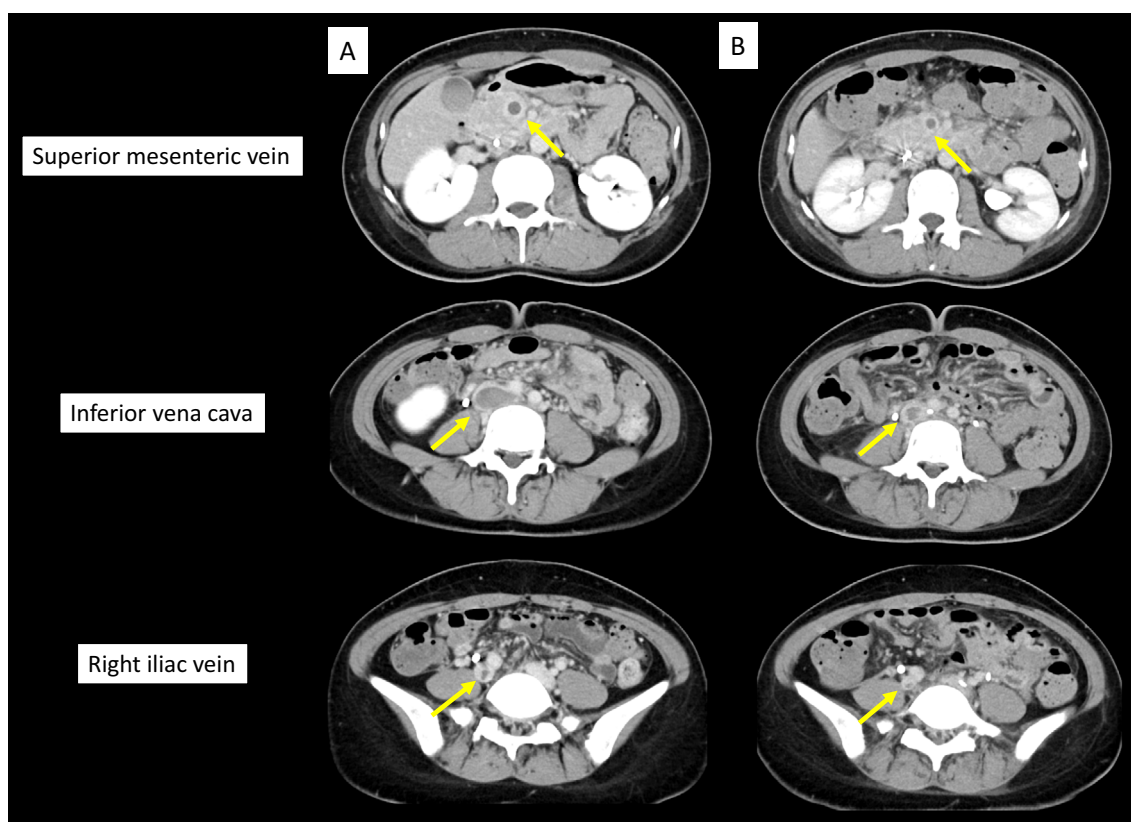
Follow-up CECT axial images of the abdomen. (A) Follow-up CECT at 7 days shows little regression of the thrombus in the superior mesenteric vein (arrow, top image), a large thrombus captured in the IVC filter (arrow, middle image), and slight regression of the thrombus in the right common iliac vein (arrow, bottom image). (B) Follow-up CECT at 12 days shows slight regression of the thrombus in the superior mesenteric vein (arrow, top image) and marked regression of the thrombus in both the IVC filter (arrow, middle image) and right common iliac vein (arrow, bottom image). CECT: contrast-enhanced computed tomography, IVC: inferior vena cava
